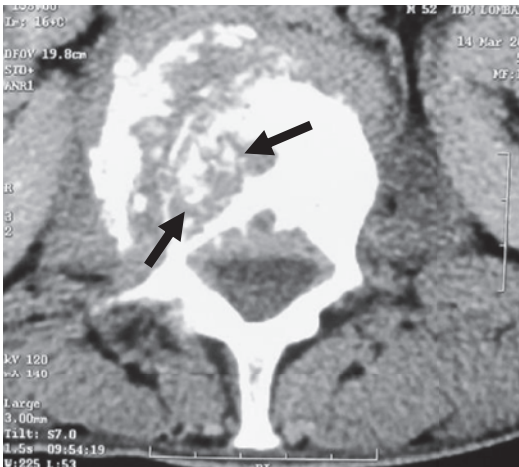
Tuberculous spondylodiscitis of the lumbar spine. Axial CT image shows multiple calcifications at the abscess wall and central area. Several sequestra (black arrows) are present in the vertebral osteolytic lesion. Epidural component is also noted
